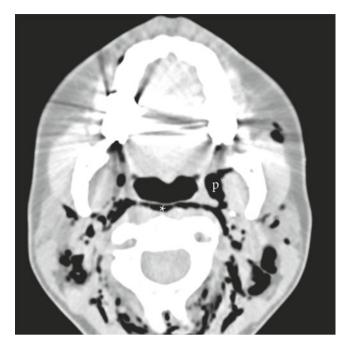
Axial CT, displayed with a "lung window" to highlight air, demonstrates extensive emphysema within the subcutaneous and deep neck spaces in this patient who also had extensive pneumomediastinum. Air fills and clearly delineates the left parapharyngeal space (p) and retropharyngeal space (*asterisk*)
